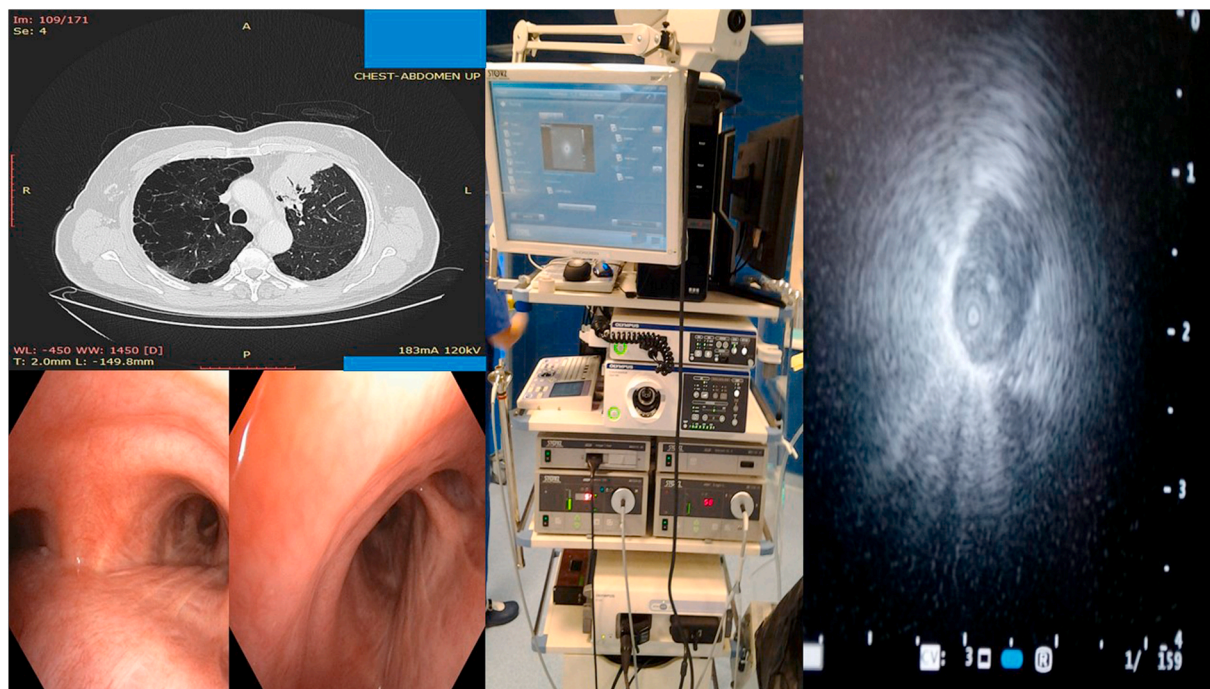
Left CT of the thorax with the cancer lesion and endobronchial images, middle the radial-EBUS equipment, and right the ultrasound image from the cancer lesion with the radial-EBUS.
